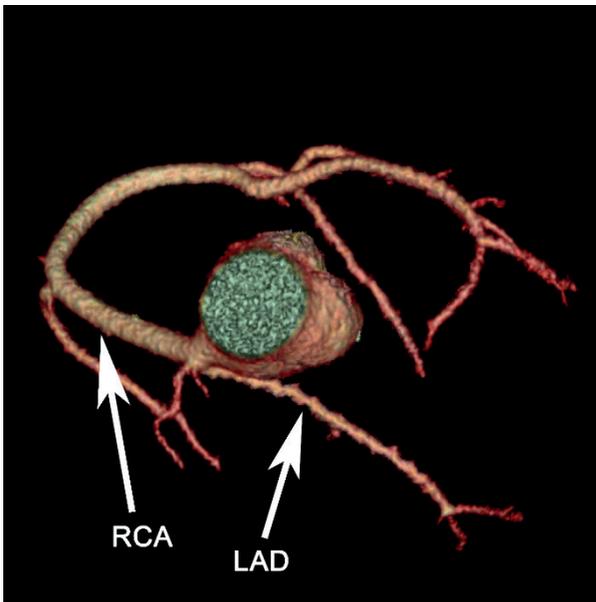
A patient with suspected coronary artery anomaly in echocardiography has a “single right” coronary artery, as depicted by CCTA.
